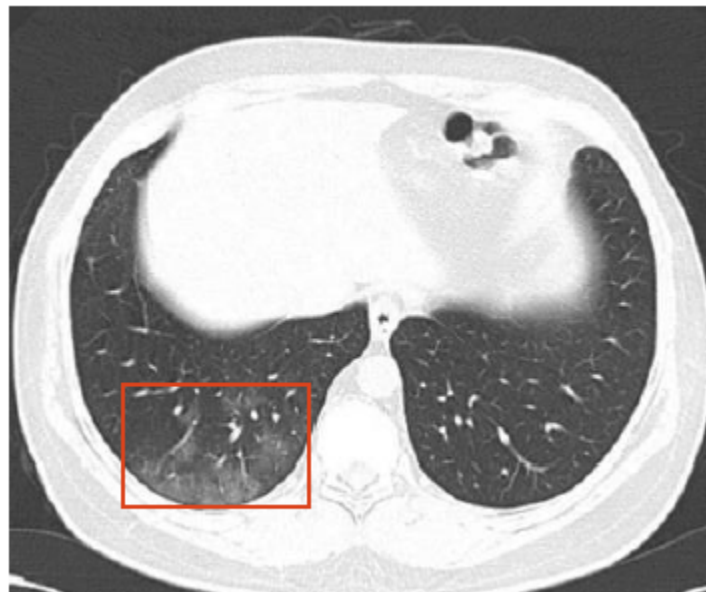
CT image of a COVID-19 positive patient with the COVID-19 disease-affected region shown as the red bounding box. Image sourced from Saburi et al. [82].
